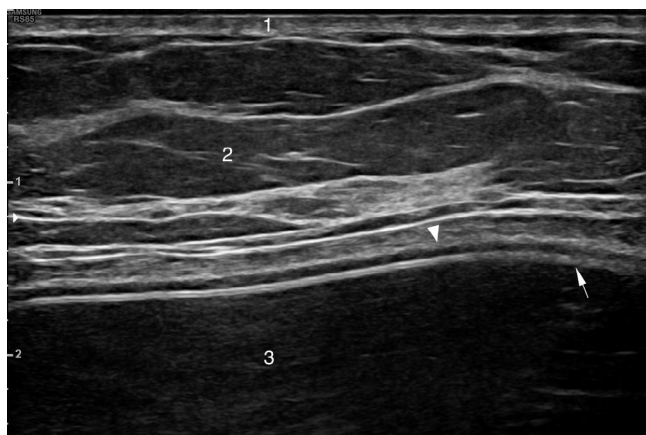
Ultrasound findings, in a transverse scanning plane, after nonsteroidal anti-inflammatory drug (NSAID) treatment: Ultrasound revealed complete disappearance of the fluid collection previously documented. Skin (1), Breast tissue (2), Breast implant (3), Implant shell (arrow), Implant capsule (arrowhead)
